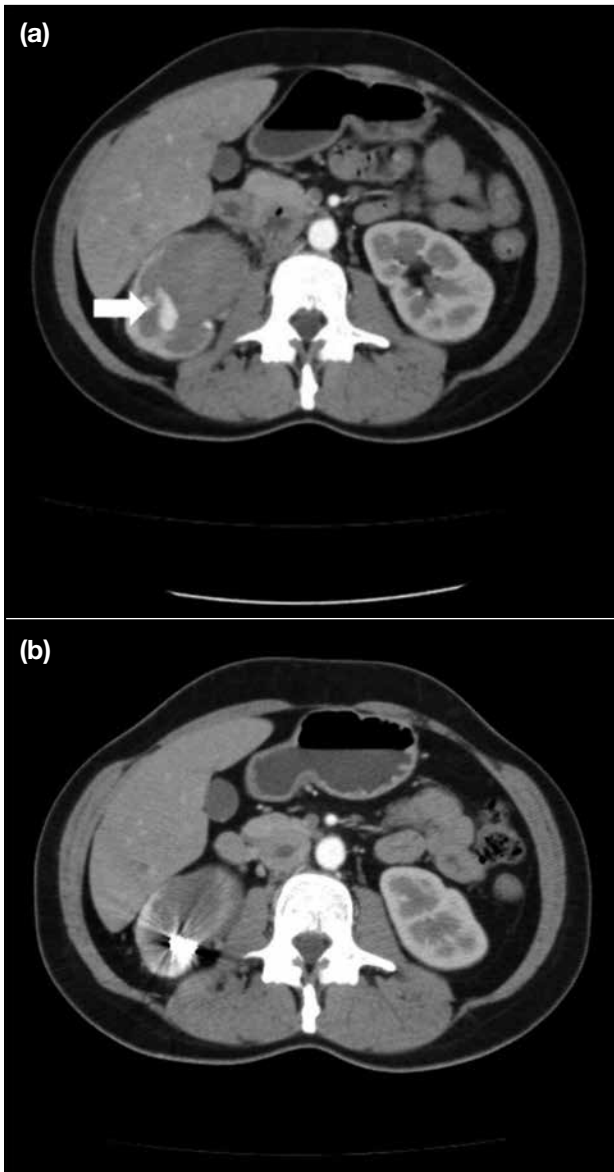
Axial contrast-enhanced arterial phase computed tomography image showing bleeding into the angiomyolipoma.
